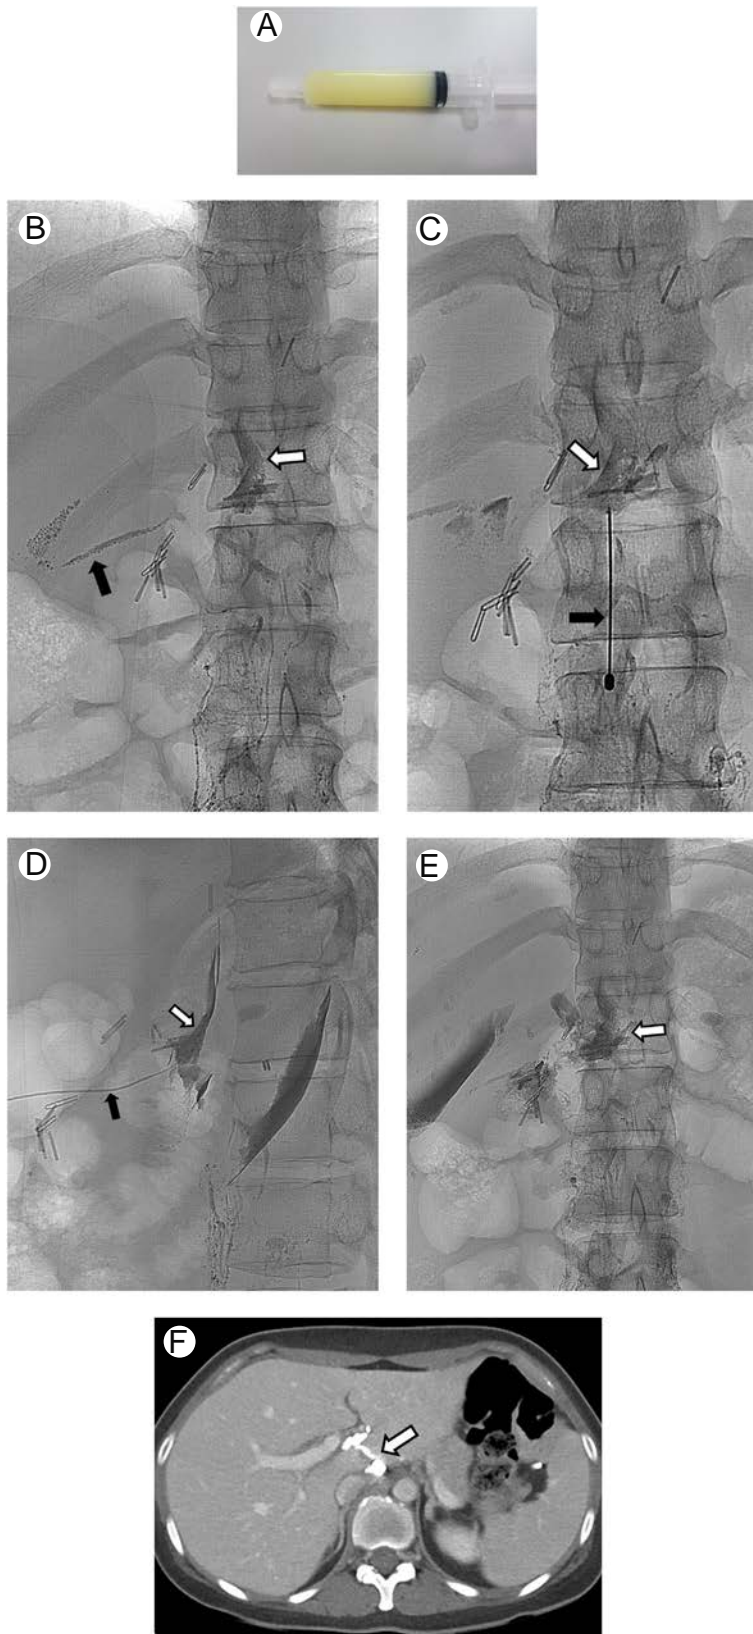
A 31-year-old female patient who developed abdominal distension after surgery for advanced gastric cancer. (A) Percutaneous drainage was performed to evacuate the intraperitoneal fluid which was found to have “milky” appearance. (B) Intranodal lymphangiography revealed a leak (white arrow) at the level of the thoracolumbar junction and the extravasated Lipiodol (black arrow) was seen to flow toward the perihepatic space. (C) A 21-gauge needle (black arrow) was used to percutaneously access the site of the leak (white arrow). (D) After inserting a 0.016-in guide wire (not shown) through the needle, the needle was exchanged for a 2.4-Fr microcatheter (black arrow) in a coaxial fashion after which NBCA-Lipiodol mixture of 1:1 ratio was injected into the leak (white arrow). (E) A glue cast (white arrow) is seen on spot radiography that was acquired immediately after embolization. (F) CT performed 2 months after embolization shows trace of embolic material (white arrow) at the prior leakage site. The peritoneal cavity is free from chylous ascites.
